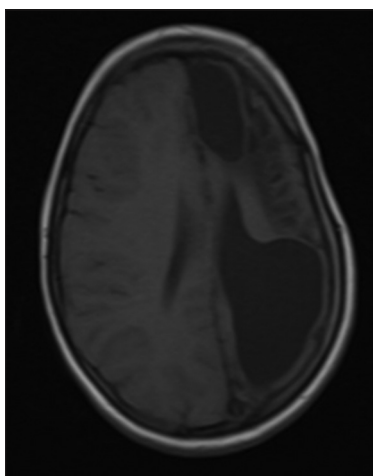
T1W MRI image showing calvarium thickening
